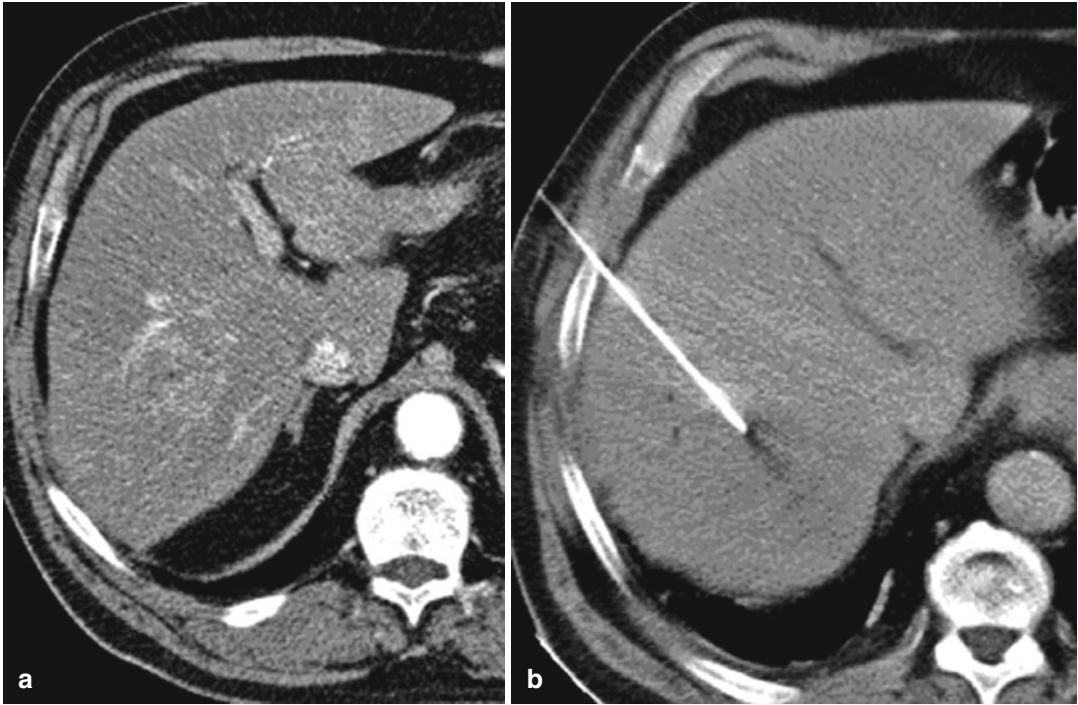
Anterolateral intercostal approach to an unclear focal liver lesion enhanced slightly during arterial-phase computed tomography (CT) (a) in liver segment 5/8 in a
